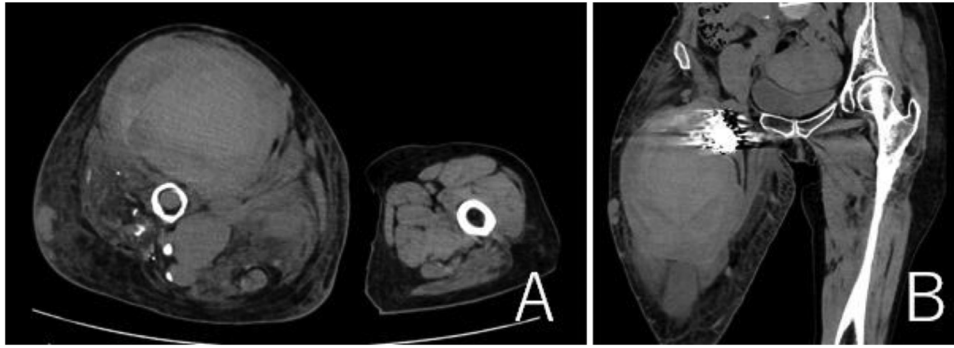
Findings of CT 2 month after discharge. (A, B) CT revealed more expanded pseudoaneurysm (131 x 107 x 180 mm).
